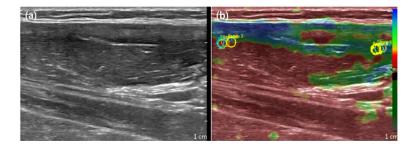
Ultrasound image (A) and Elasto image (B) of forearm after infrared therapy. ROI 1-cm away from anterior compartment of forearm to brachioradialis muscle of the upper extremity.
